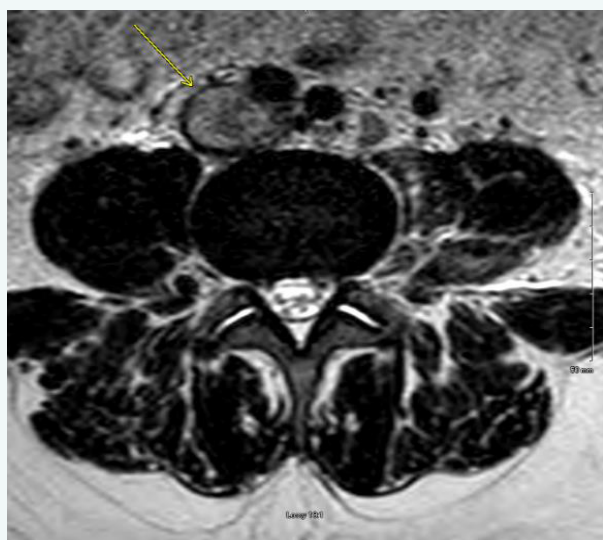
Abdominal MRI revealed IVC thrombosis as indicated with the yellow arrow.
